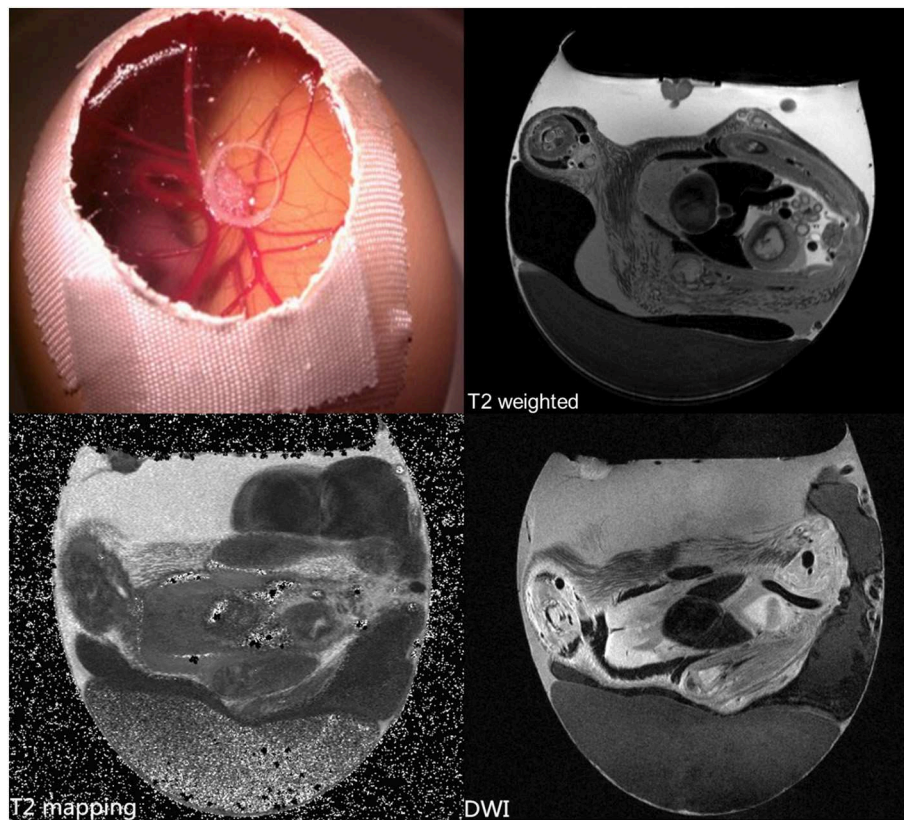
In vivo* high-resolution MRI with T2 and diffusion weighting (DWI), and T2 quantification of a Human breast tumor (carcinoma cell line MDA-MB-231) xenotransplanted on the CAM. Unpublished imaging material provided by Zuo obtained with precooling and MR protocols as described in [61].
